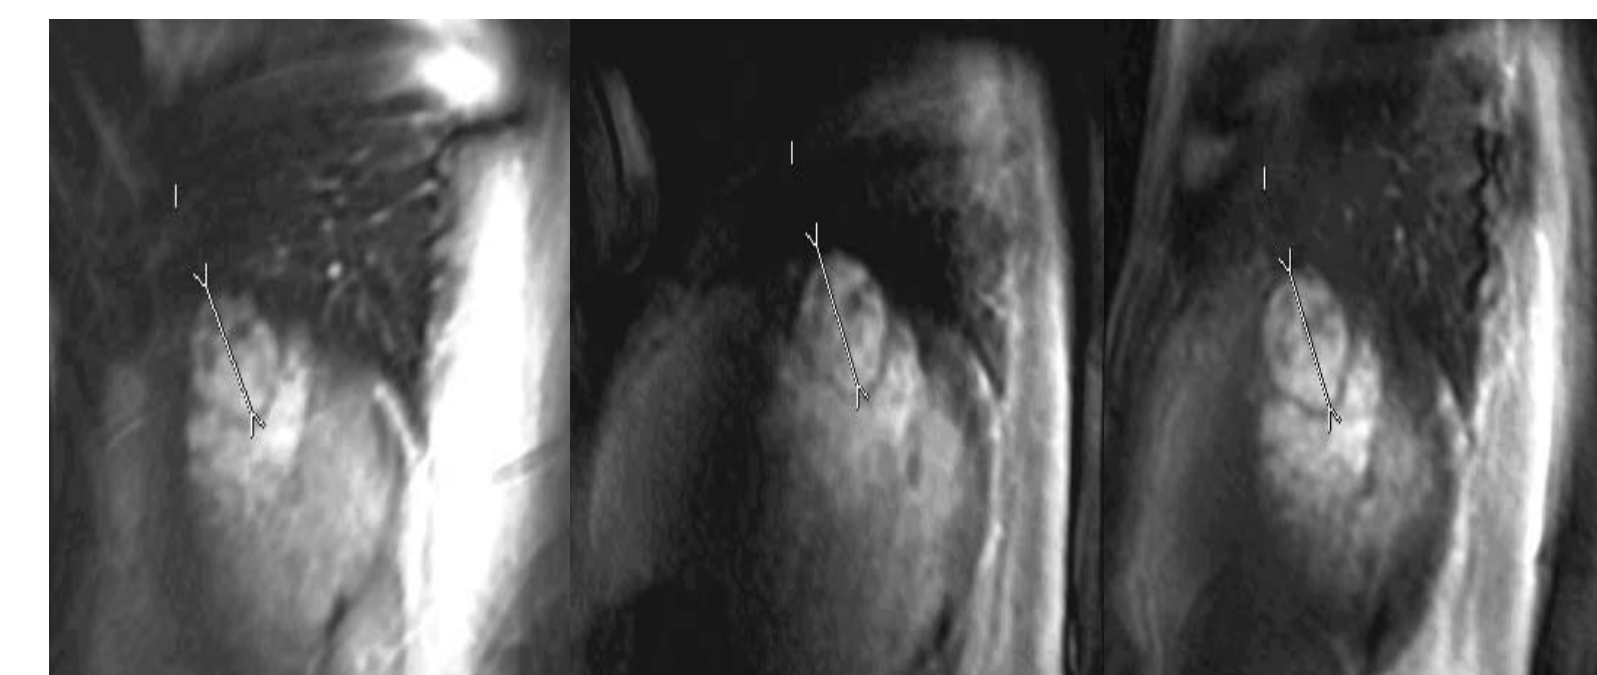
Serial MRI and AFP of patient 1
